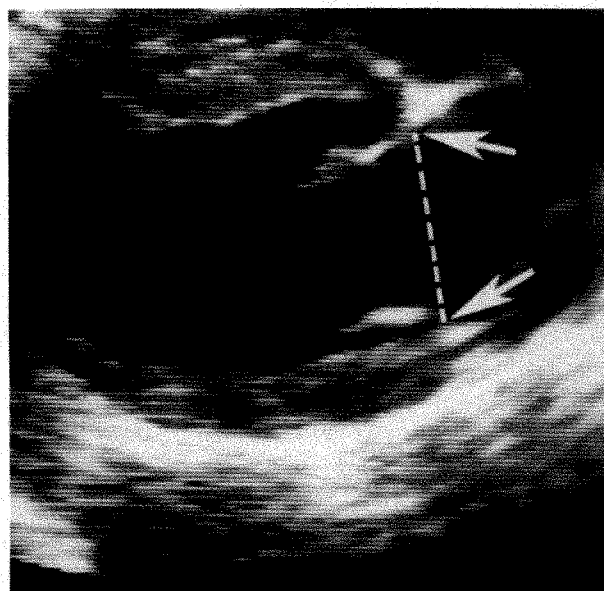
Parasternal long-axis view of left ventricle. Arrows indicate insertion points of mitral leaflets.
